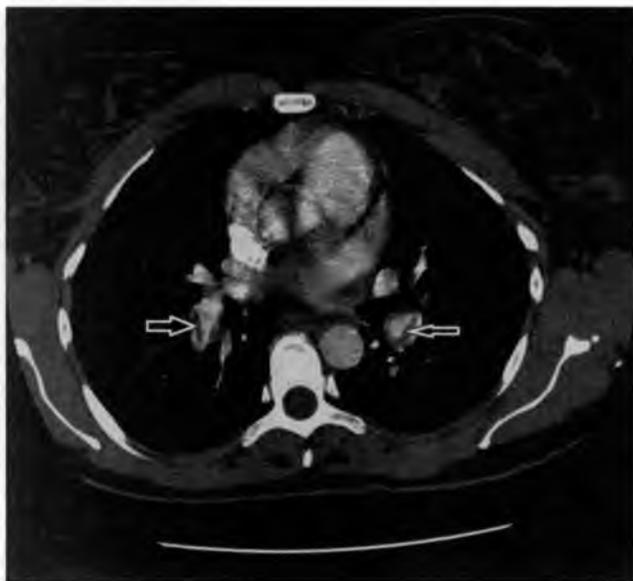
Computed tomography pulmonary angiogram of pulmonary embolism (arrows pointing to embolism in pulmonary arteries).
